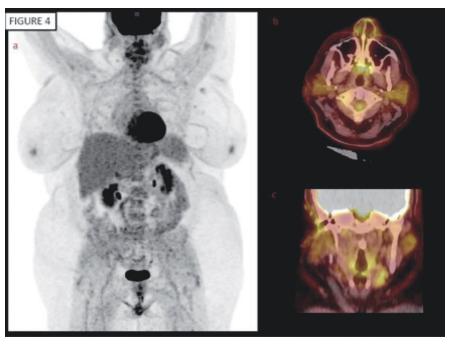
A post treatment (Prednisone) FDG pet scan in a patient with sarcoidosis and Sjögren syndrome. Physiological uptake was seen, with an uptake less than the blood pool, suggesting a favourable treatment response. Moderate hypermetabolism was seen in salivary glands: a) whole body, b) axial and c) coronal images.
